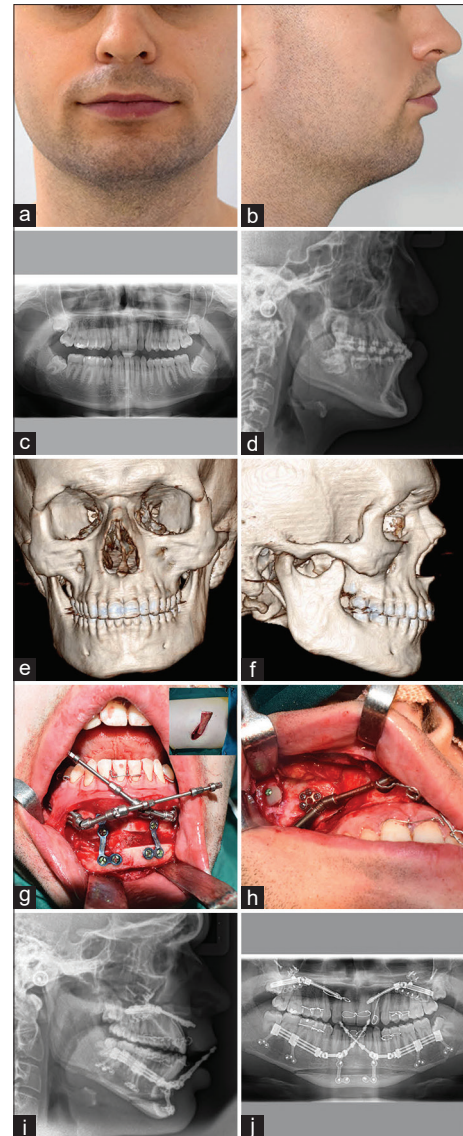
(a-f) Preoperative view showing decreased lower facial height. (g) Intraoperative view showing vertical augmentation genioplasty using rib graft and mandibular ramus distractor fixed bilaterally with activating arm exiting outward. (h) Zygoma augmentation using rib graft and Le-Fort I distractor in place. (i and j) Postoperative orthopantomogram and lateral cephalogram taken at the end of the bilateral mandibular body and maxillary distraction osteogenesis
